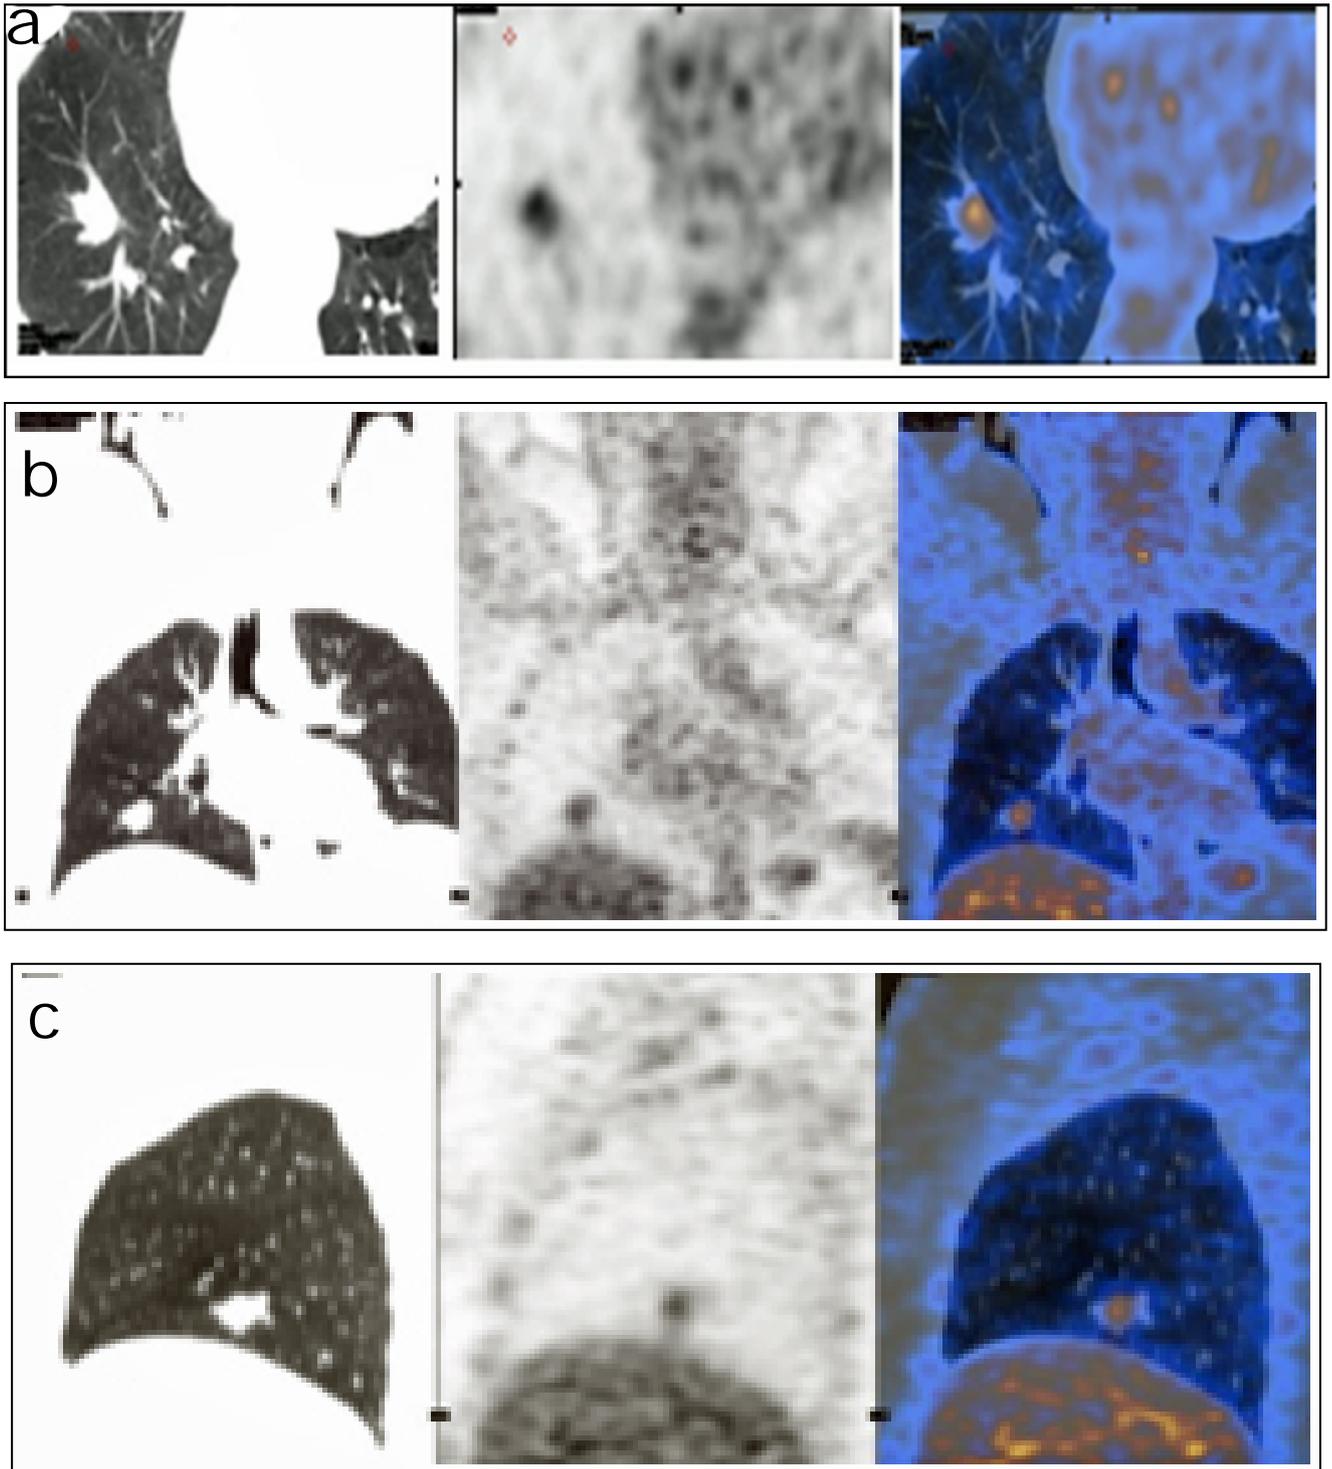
PET-CT scan showing PET image (left row), the CT image (middle row), and the fused image (right row) in the transaxial (a), coronal (b) and sagittal (c) axes. The PET component shows an FDG-avid (SUV_{max} 4.3) nodule in the lower lobe of the right lung. The CT component shows a mass-like para-hilar lesion in the lateral segment of the right lower lobe of the lung. The fused images show the focal increased FDG uptake to correspond to the mass-like lesion
